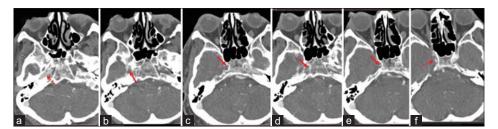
Axial cerebral computed tomography angiography images. (a) Patent internal carotid artery in the petrous portion (jagged arrow). (b-e) Critical stenosis of the right internal carotid artery in the cavernous segment (obvious in the images of c and d, arrows). (f) Image showing the patent flow at the supraclinoid segment of the right internal carotid artery (jagged arrow)
